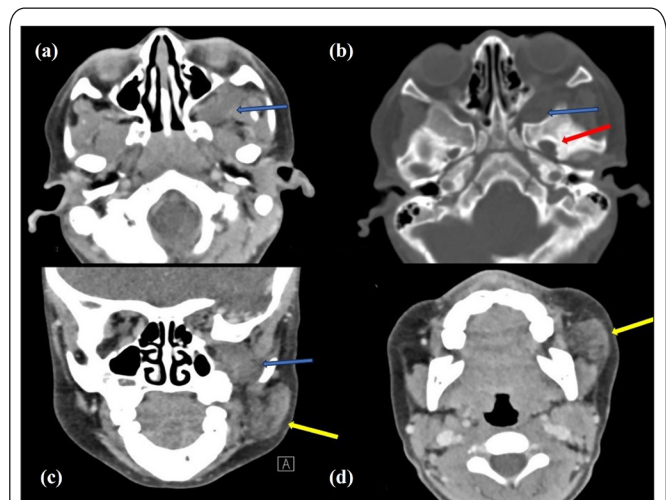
Contrast-enhanced CT facial bones. (a) Asymmetric soft tissue mass is present within the left pterygopalatine fossa (blue arrow), which extends laterally into the infratemporal fossa/masticator space through the pterygomaxillary fissure. (b) Axial imaging optimized for visualization of bony structures show the left pterygopalatine fossa mass asymmetrically widening the left inferior orbital fissure (blue arrow), left foramen ovale (red arrow), with corresponding bony remodeling. (c) Coronal image reveals the left pterygopalatine fossa soft tissue mass expanding the left inferior orbital fissure (blue arrow), in addition to an asymmetric soft tissue density anterior to the left parotid gland, superficial to and extending slightly anterior to the left masseter muscle (yellow arrow). This soft tissue density projects superiorly toward the left pterygopalatine fossa mass, and thus was suspected to be a contiguous extension. (d) Axial image confirms the asymmetric soft tissue density immediately anterior to the left parotid gland.
